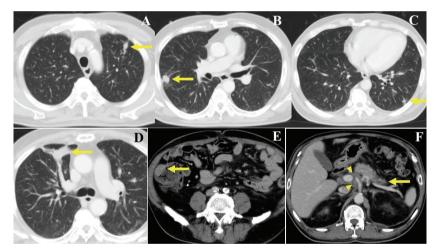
Initial CT before the treatment. (A-C) Multiple lung nodules of varied sizes at bilateral lungs (arrow) were noted in the chest CT. (D) Patchy opacity consolidation was seen in the right upper lobe (RUL) (arrow). (E) A 2-cm mass is shown at the ascending colon (arrow). (F) Enlarged abdominal lymph nodes (arrowhead), and atrophy of the pancreatic tail with a dilated pancreatic duct (arrow) are seen in the abdominal
